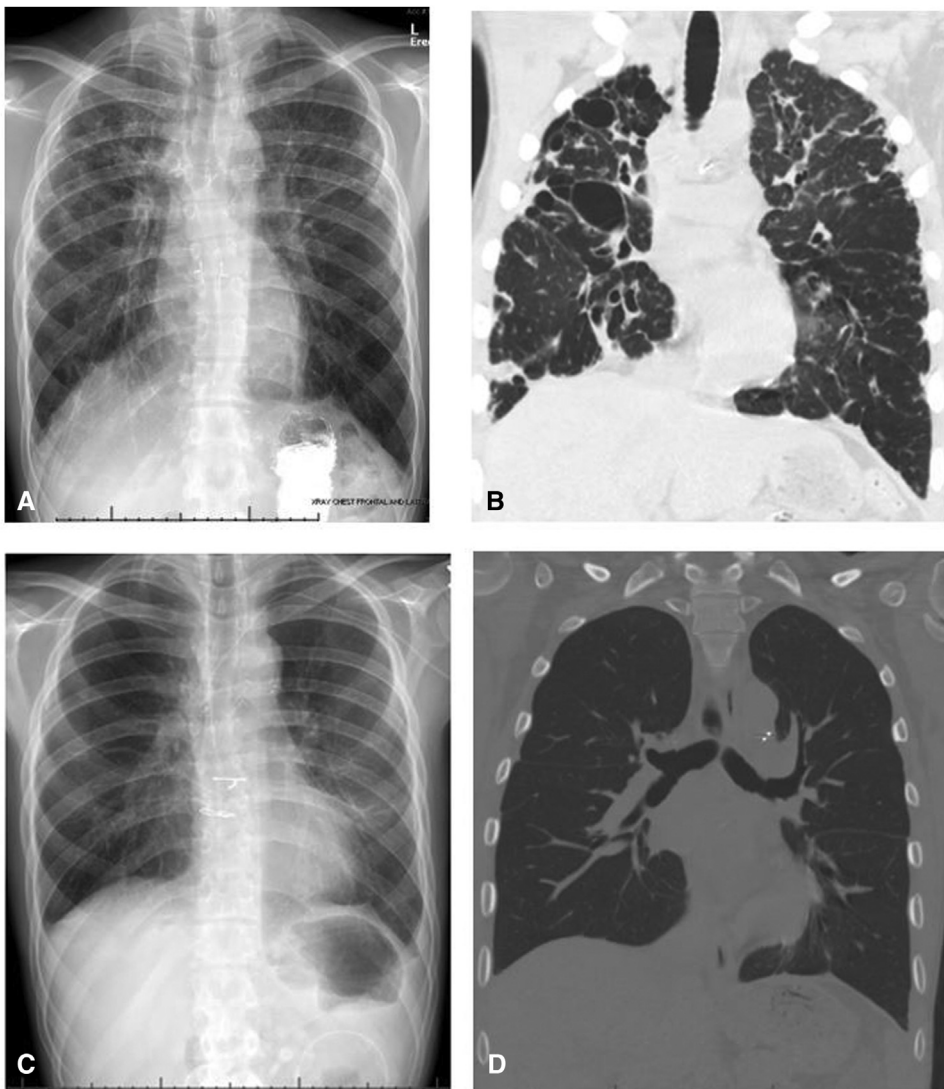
Radiographic imaging pre- and post-transplant. A, Chest radiograph at the time of listing. B, Coronal chest computed tomography at the time of listing. C, Discharge chest radiograph. D, Coronal chest computed tomography 3 months after transplant.
